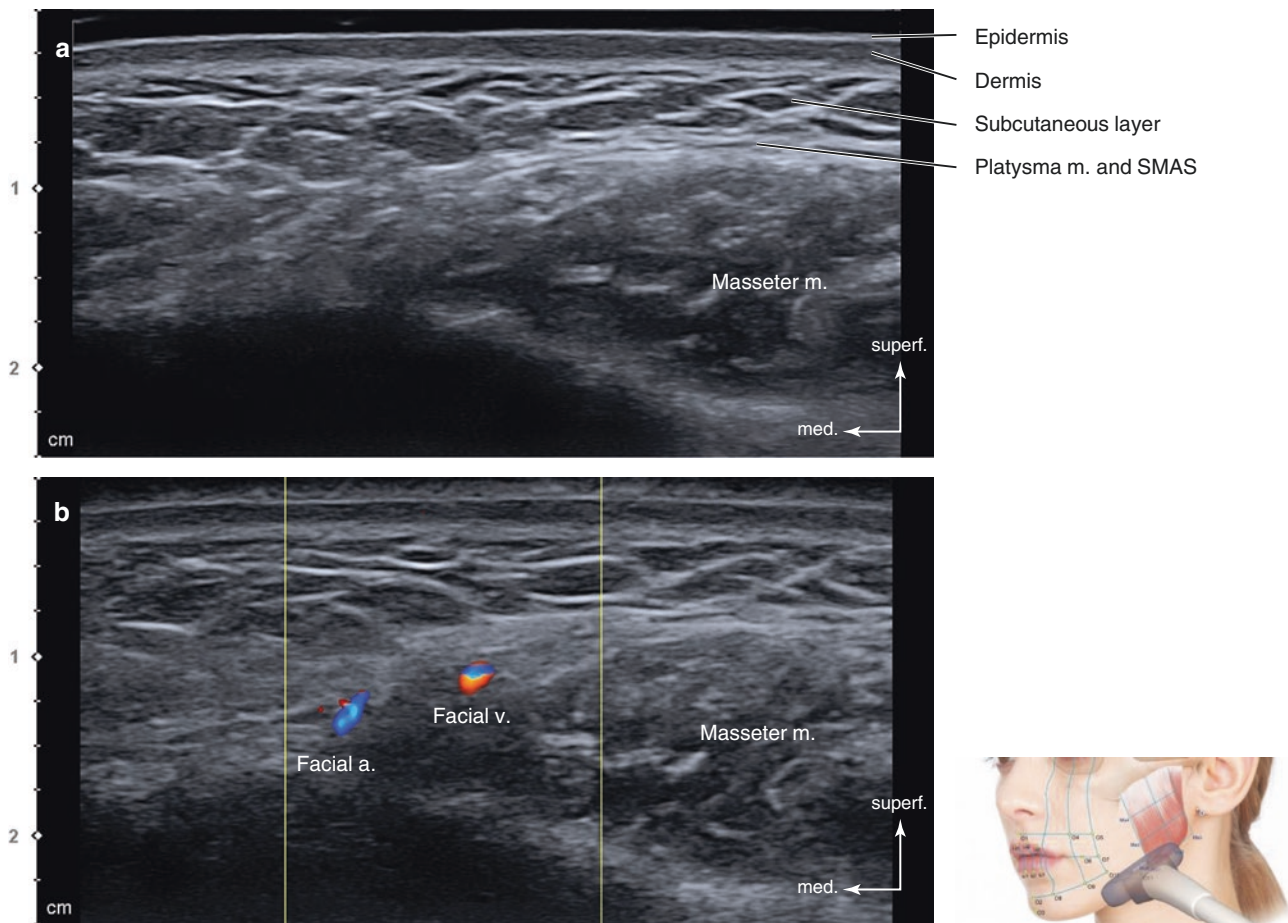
Ultrasonography of the antegonial notch (O11). (a) B mode (transverse view, 15 MHz by linear transducer) and (b) Doppler mode (transverse view, 15 MHz by linear transducer). (Published with kind permission of © Hee-Jin Kim 2020. All Rights Reserved)
